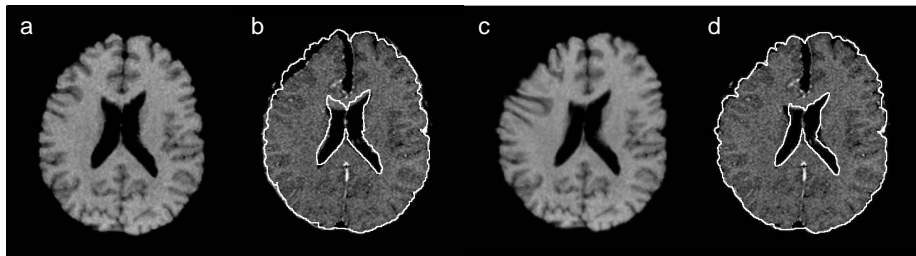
Rigid and non-linear registration applied to MR images of the brain. a) Slice image at the beginning of the surgery. b) The corresponding rigidly registered slice of intraoperative scan overlaid with the contours of initial scan. c) Non-linearly deformed image a). d) Slice of intraoperative image overlaid with the contours of deformed image
